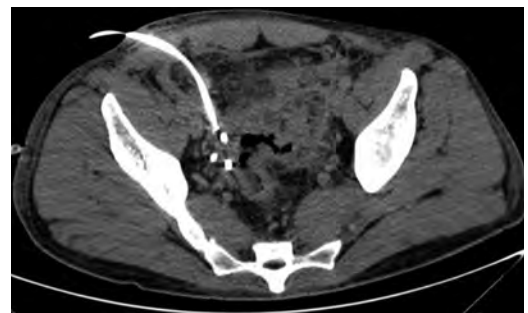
CT scan demonstrating significant size reduction in the supra vesical collection.
